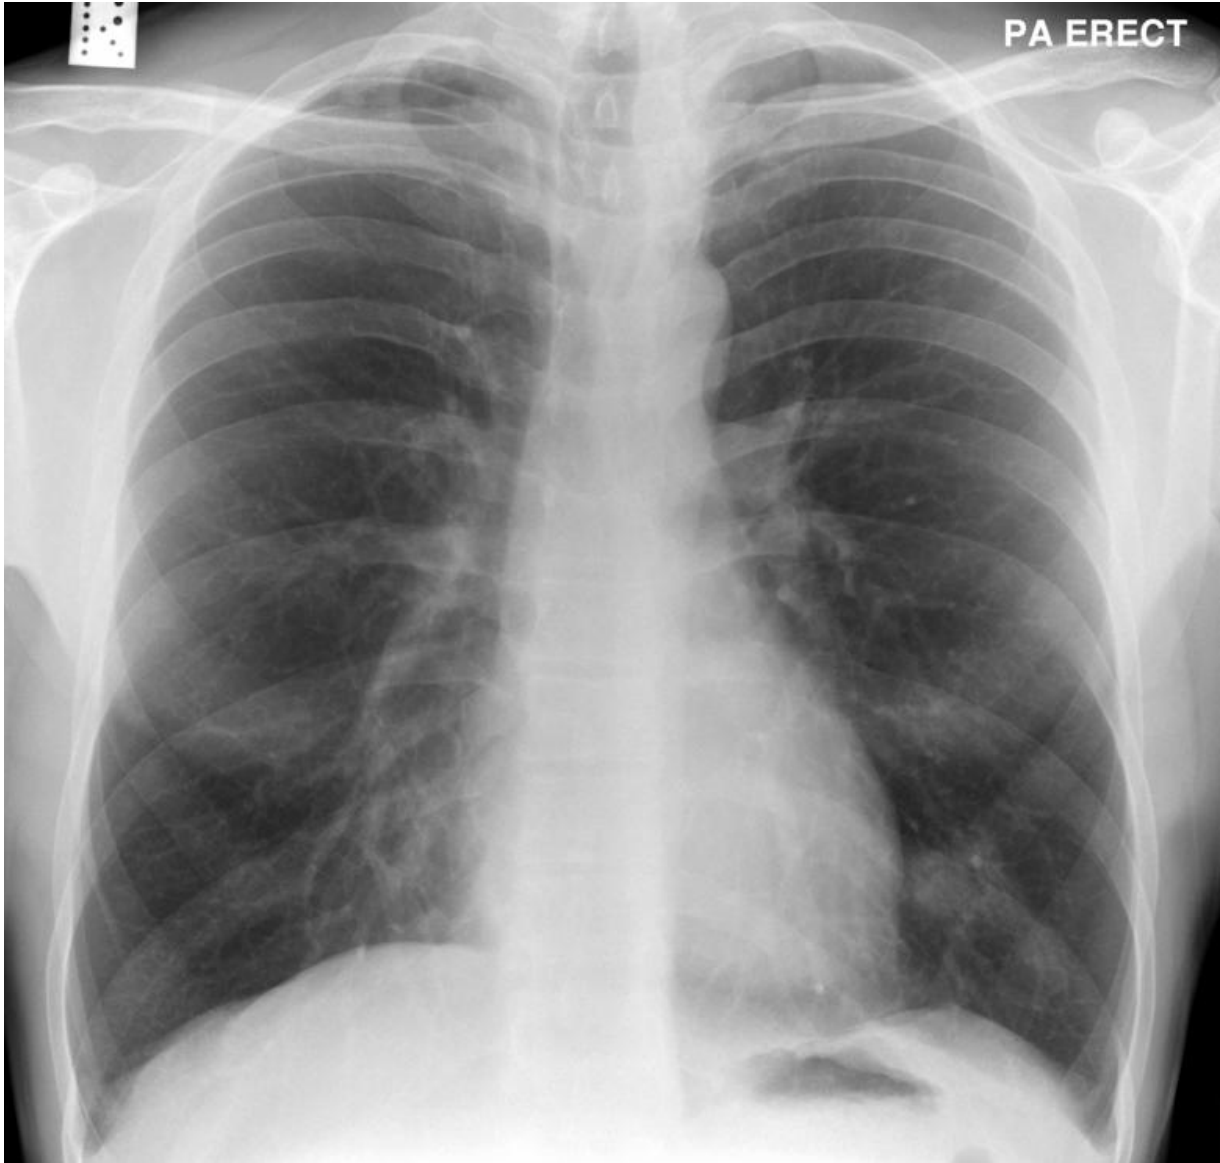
Male contact's chest x-ray 10 weeks after his partner had started anti-TB treatment.
